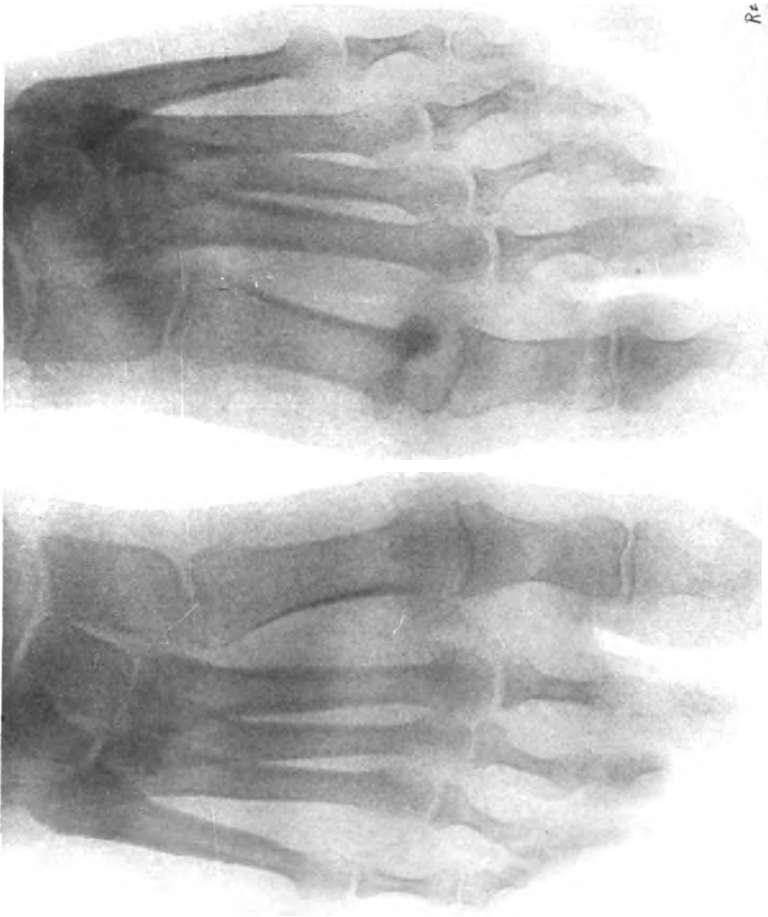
Radiograph of result after nine months.
